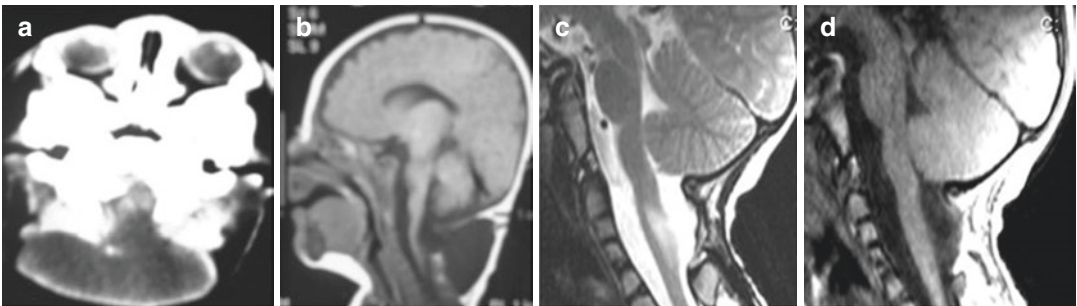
Craniocervical meningocele in a 4-month-old baby. The patient was brought due to swelling in her neck. Neurological examination was normal. There was a craniocervical meningocele on physical examination. Preoperative axial CT scan and T1-weighted sagittal MRI
